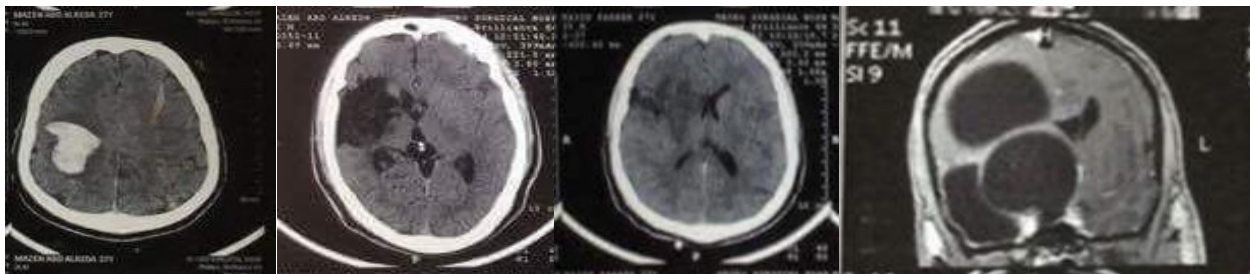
(A) Pre-operative CT scan (axial section), showing a well-defined, intracerebral hyperdensity representing intracerebral hemorrhage (ICH). (B) Post-operative cerebral CT scan (axial section) (C) Follow-up cerebral CT scan axial section shows no intracranial abnormalities. (D) FLAIR MRI coronal section showing a cystic lesion with a thin, hypointense marginal membrane with a marked mass effect causing contralateral displacement of midline structures.
